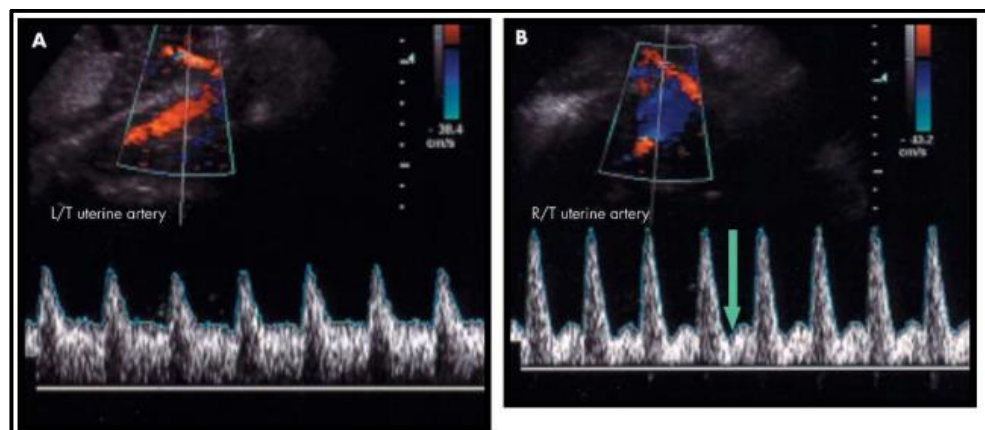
Doppler uterine artery assessment showing (A) normal flow velocity waveform with low resistance, and (B) abnormal flow velocity waveform with an early diastolic notch (arrow) and a high resistance index (James and colleague 2004)²³
